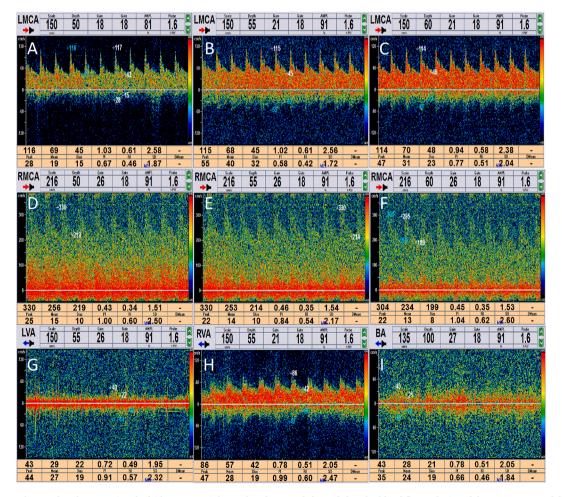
Two hours after the operation, bedside transcranial Doppler ultrasound showed that the blood flow velocity of the M1 segment of the right middle cerebral artery fluctuated between 304 and 330 cm/s (3D, E and F), the blood flow velocity of the M1 segment of the left middle cerebral artery fluctuated between 114 and 117 cm/s (3A, B and C), and the blood flow velocities of the bilateral vertebral artery and basilar artery were in the normal range (3G, H and I). The PI and RI values of all vessels were in the normal range (3A-I).
